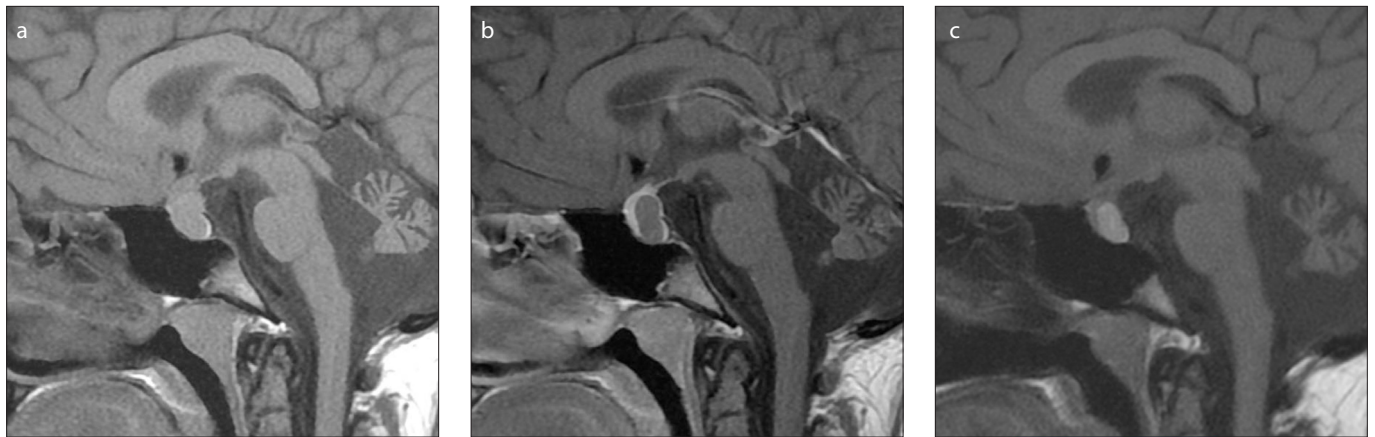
a–c. An RCC that is isointense to the anterior pituitary gland on unenhanced T1-weighted image (a) and hypointense on sagittal contrast-enhanced T1-weighted image (b). Sagittal unenhanced T1-weighted image (c) shows the signal intensity change of the RCC during follow-up of the same patient.
